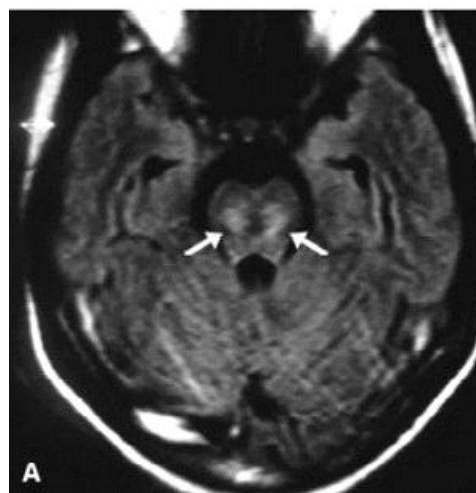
MRI imaging using DWI showing hyperintensities in the pons
